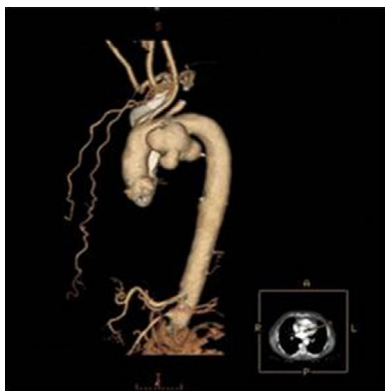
Contrast-enhanced thoracic computed tomography with sagittal reconstruction, showing a saccular aneurysm of the aortic arch.
